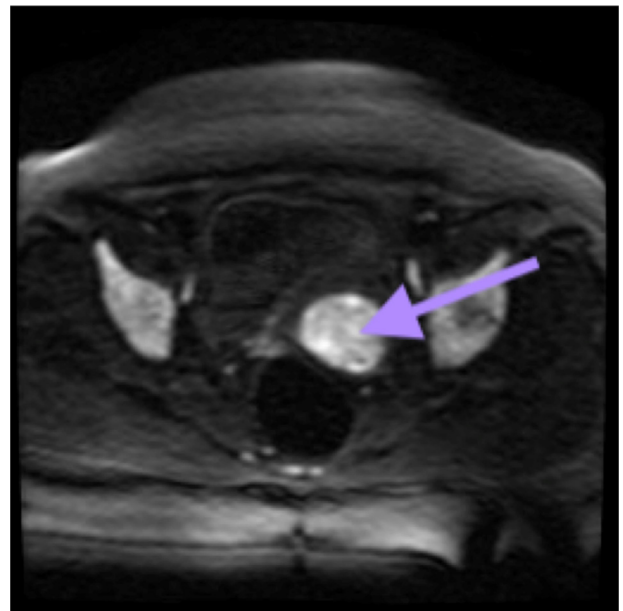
Axial DWI view of the tumor on MRI.
